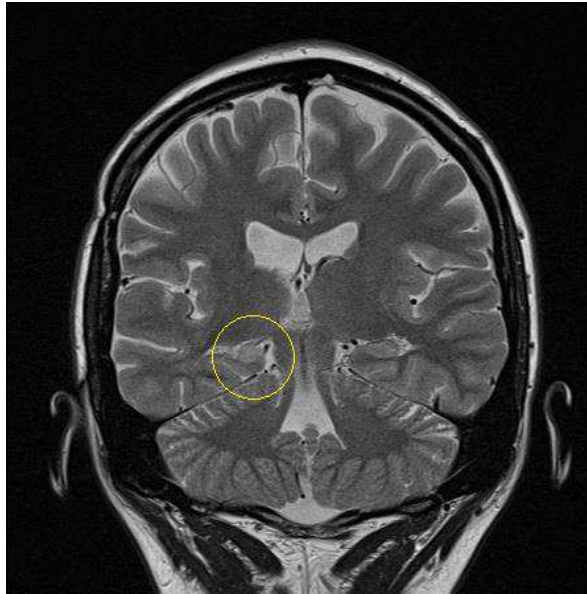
MRI T2 sequence. Coronal plane. Right hippocampal sclerosis.
